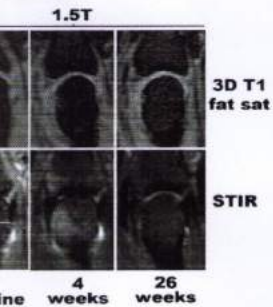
MRI scans showing osteitis (arrowheads) in the metacarpal head between baseline and 4 weeks. The baseline 0.28T 3D T1 sequence showed an erosion (arrow) at 4 weeks which is not easily seen on the 1.5T 3D T1 sequence.
